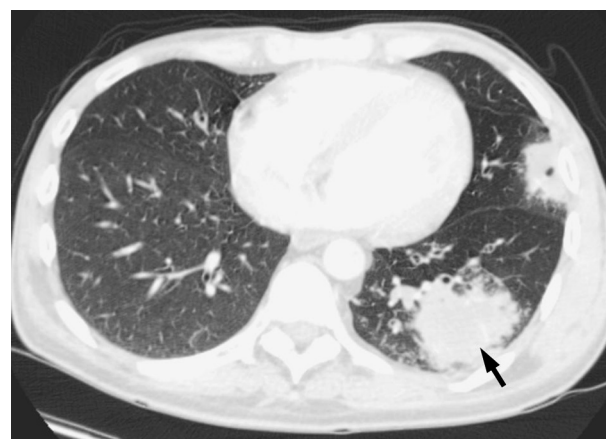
Axial CT image showing a large subpleural ‘target lesion’ in the left lower lobe (arrow) and a smaller nodule in the lingula in a patient with invasive pulmonary aspergillosis (IPA). Such macronodules typically have a rim of ground-glass opacity (the halo sign) representing haemorrhage and vascular invasion.
